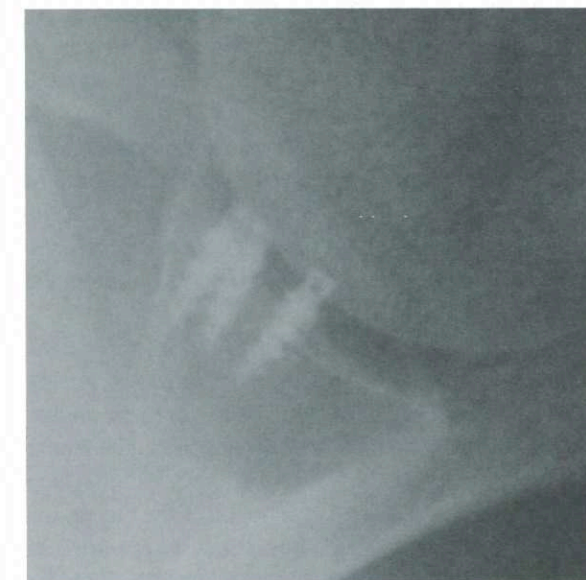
An axillary radiograph revealing multiple, ineffective, anteriorly placed anchors for a SLAP repair. One double loaded anchor correctly placed at the biceps origin is sufficient for a type II SLAP repair
